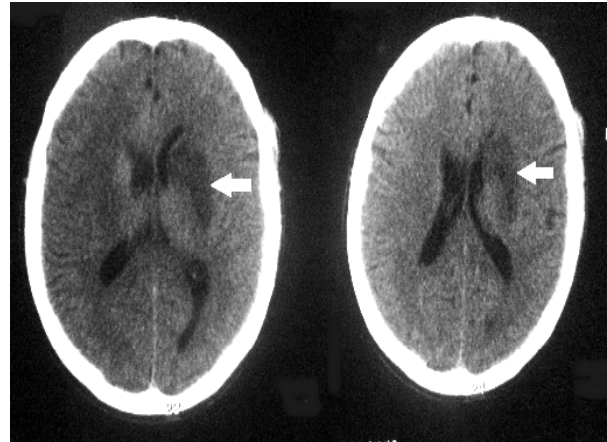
Computed tomography of the skull without contrast revealing hypodensity compatible with recent ischemic process in territory of the left choroidal artery.*
